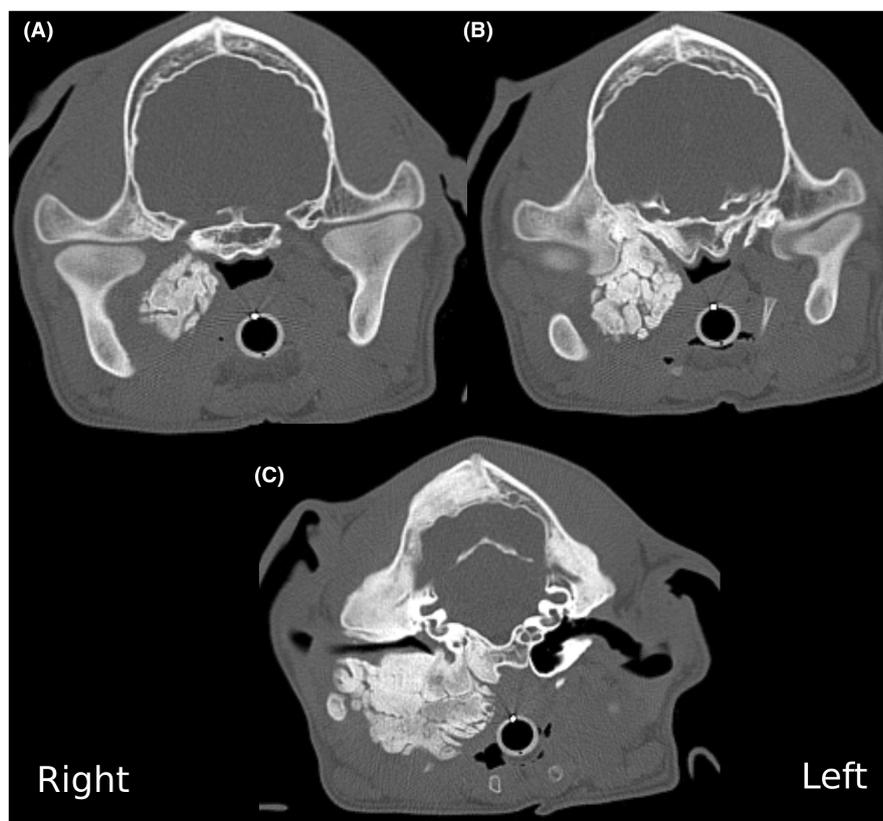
CT study of the skull in bone algorithm from rostral to caudal (A–C), showing the mass-like lesion at the right temporomandibular region, with increased bilateral thickness and hyperattenuation of the temporal, parietal, and occipital bones. Both temporomandibular joints are within normal limits.
